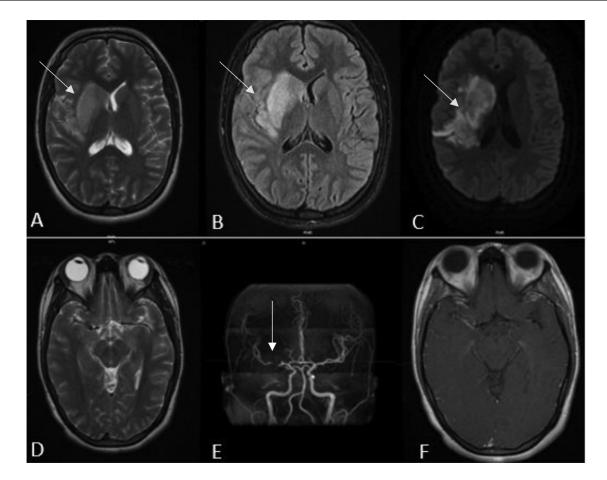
(A, B) Axial T2 and FLAIR showing ischemic area in the territory of the right middle cerebral artery. (C) Diffusion. Area of restricted movement of water molecules in the right middle cerebral territory. (D) Axial T2 showing irregular and alteration in the normocology of the signal vacuum of the right middle cerebral artery. (E) MIP showing thinning and suspected dissection of the M1 segment of the right middle cerebral artery. (F) Axial T1 with contrast with enhancement of the wall of the right middle cerebral artery.
